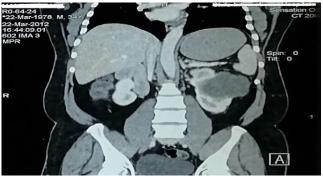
Abdominal computed tomography coronal view.
